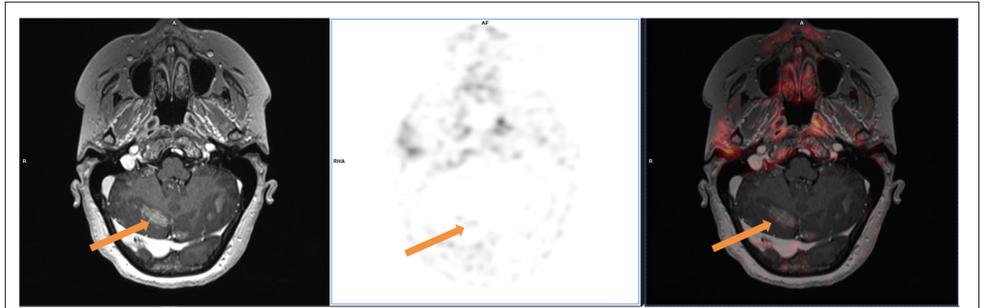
Leptomeningeal disease in a patient with HER2-negative breast cancer confirms very low tracer accumulation in known lesion. MRI, PET and PET/MRI fusion from left to right.
